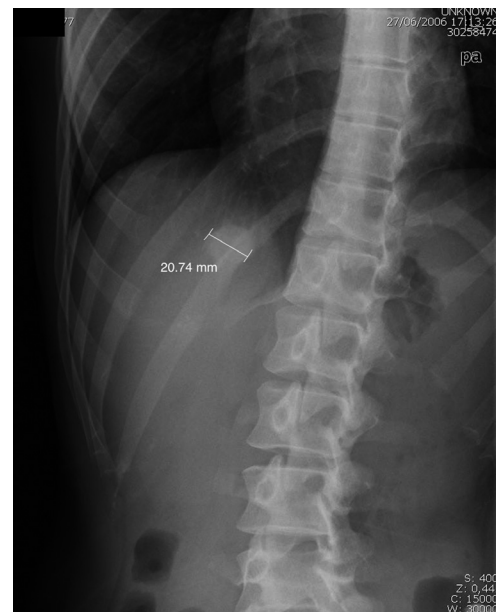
Chest/abdominal X-rays showing a 2 cm diameter ground lesion in inferior right lung lobe.
